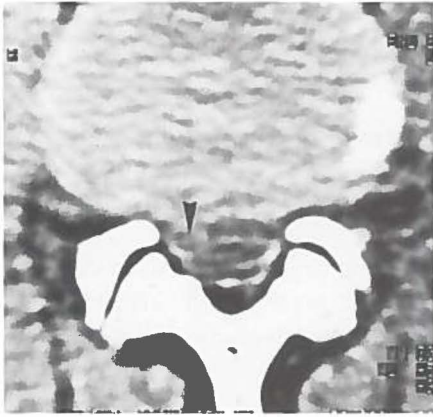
Case 5. CT scan of disc level L4-L5, demonstrating a small right sided posterolateral herniated disc (arrowhead).
